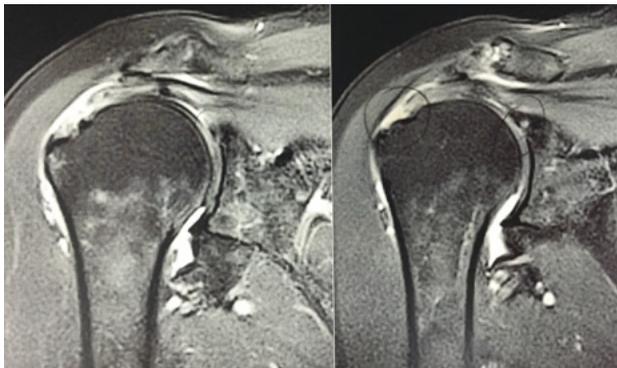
Magnetic resonance image (coronal view) showing a tear in the supraspinatus tendon.
